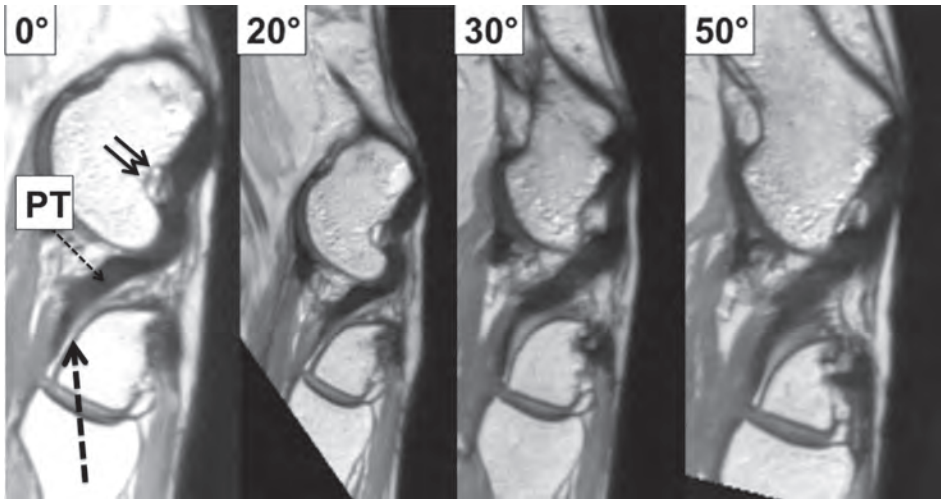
These images were obtained with a 7 Tesla MRI from 0° to 50° of flexion. The slices are oblique and aligned with the Popliteus tendon (PT) from its insertion at the level of the lateral epicondyle (double black arrow) down to its contact with the lateral tibial plateau. In the posterolateral area, the PT is in close contact with the lateral plateau through a cartilaginous surface (dotted black arrow).
